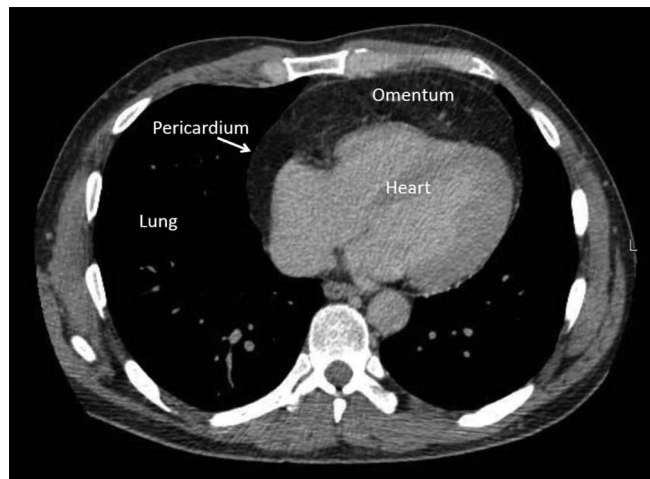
CT scan of chest 2 months after injury.
